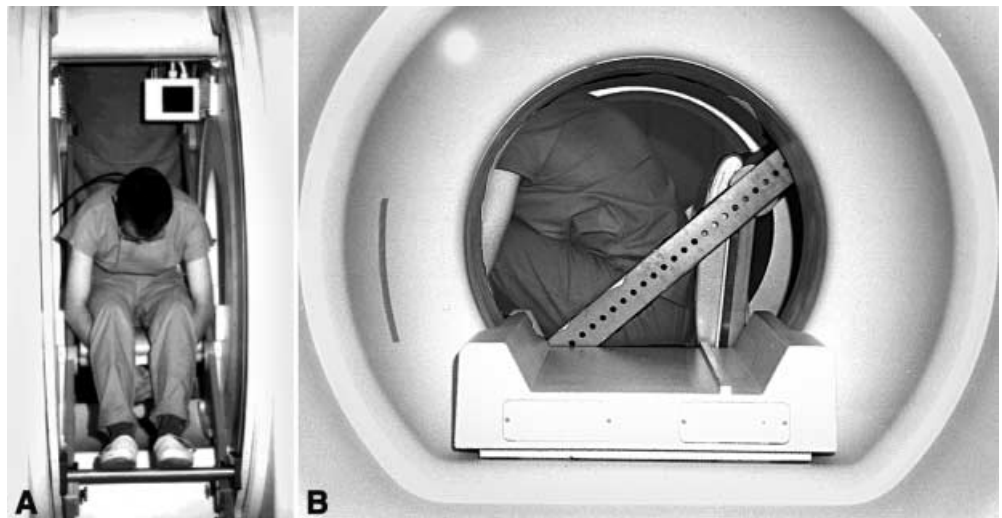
Vertical open magnetic resonance imaging (MRI) system GEMS Signa SP.5T and amagnetic chair for the examination (inlet)
